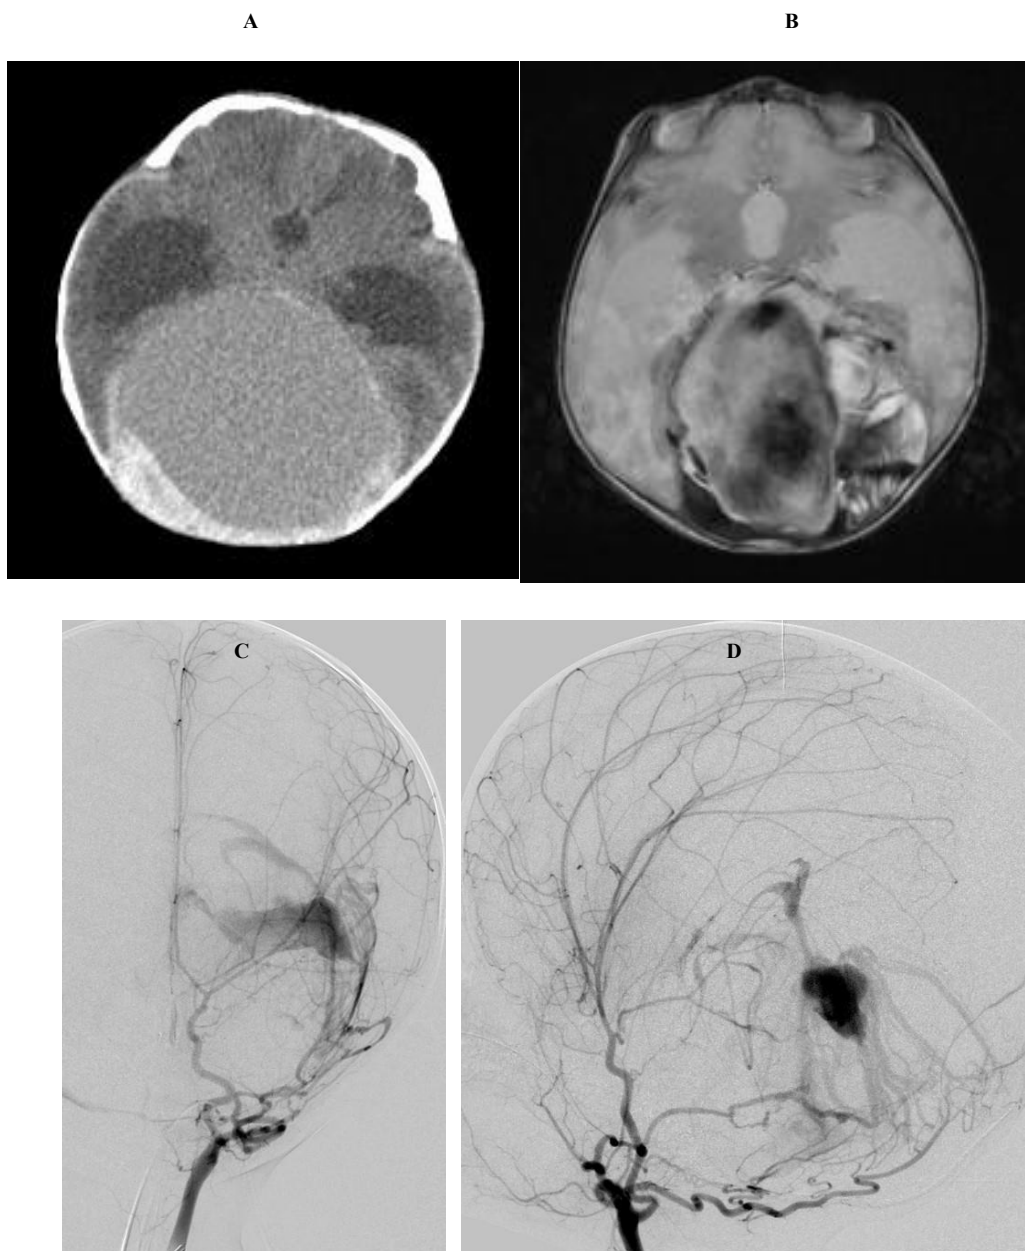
DSM of a newborn boy initially suspected a brain tumor by the intrauterine ultrasound and MRI.
